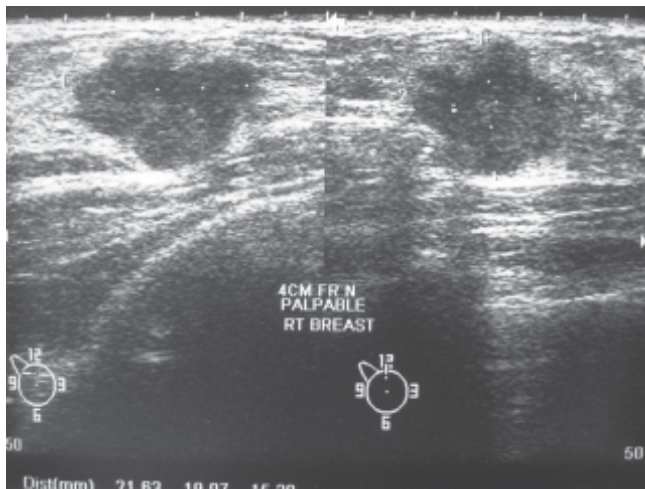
Horizontal and transverse sections of the palpable lump at the 12 o'clock position on ultrasonogram. There is macro-lobulation, although there is no acoustic shadowing.
